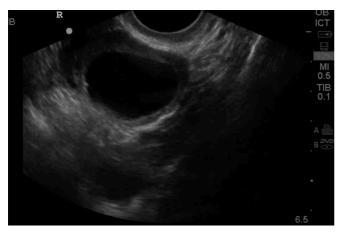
Simple ovarian cyst seen on transvaginal ultrasound.
